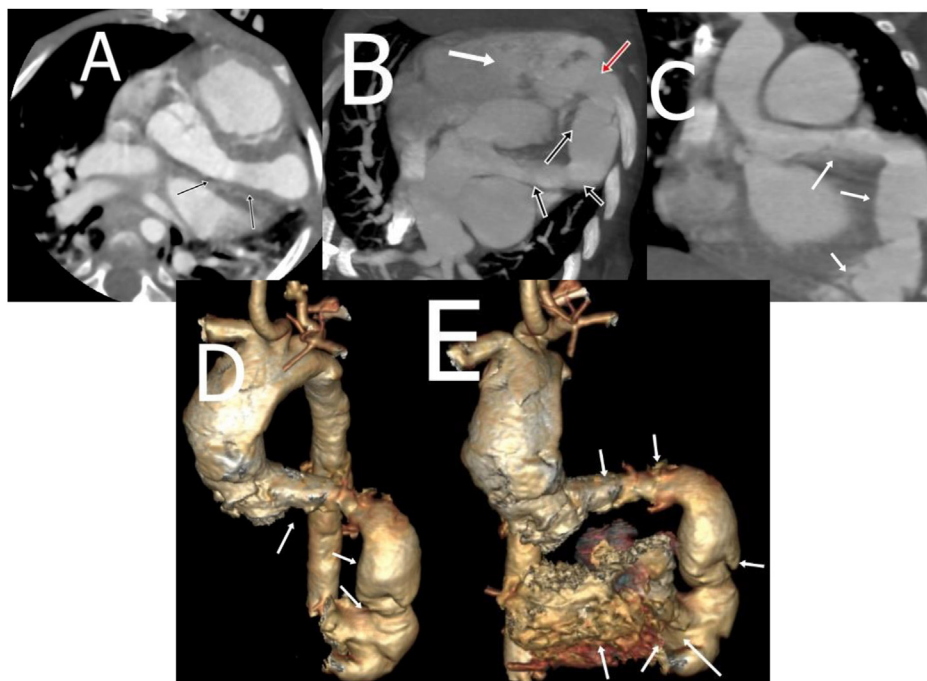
Left anterior descending right ventricle (LAD-RV) fistula (A) axial oblique computed tomography angiography image showing dilated left coronary artery and left anterior descending, (B) curved planar reformatting image showing dilated left anterior descending (black arrows), fistulous opening (red arrow) communicating with RV (white arrow), (C) coronal oblique, (D) VR cardiac computed tomography angiography showing dilated left anterior descending along its course. (E) VR cardiac computed tomography angiography image showing left anterior descending right ventricle fistula.
